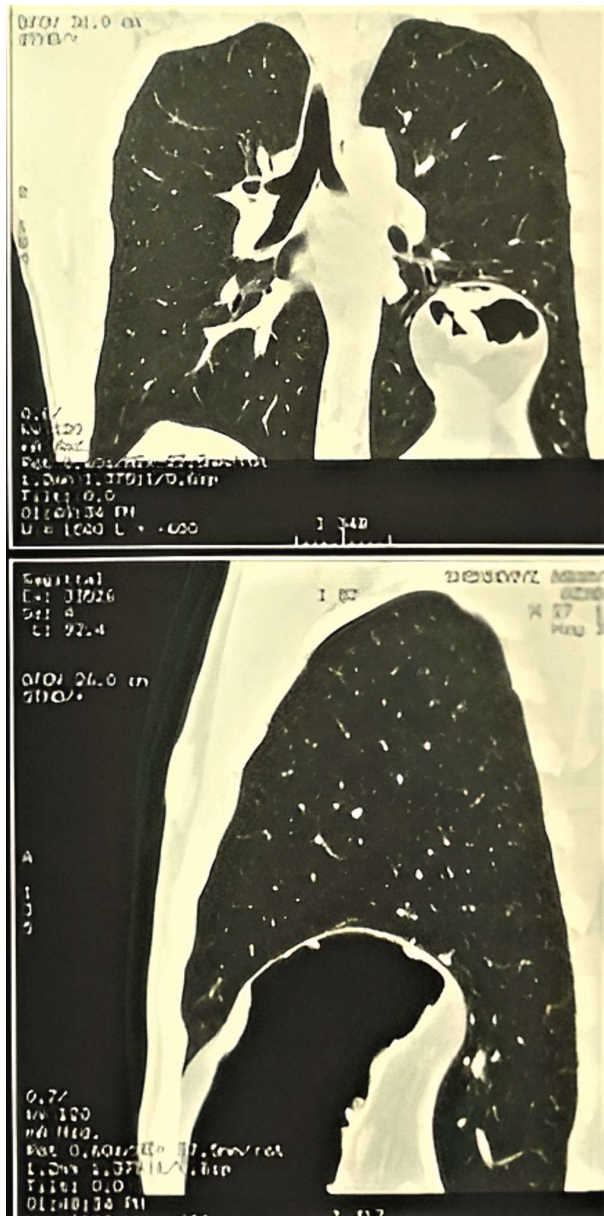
Chest computed tomography scan (axial view): The presence of abdominal organs on the left side of the thorax.
